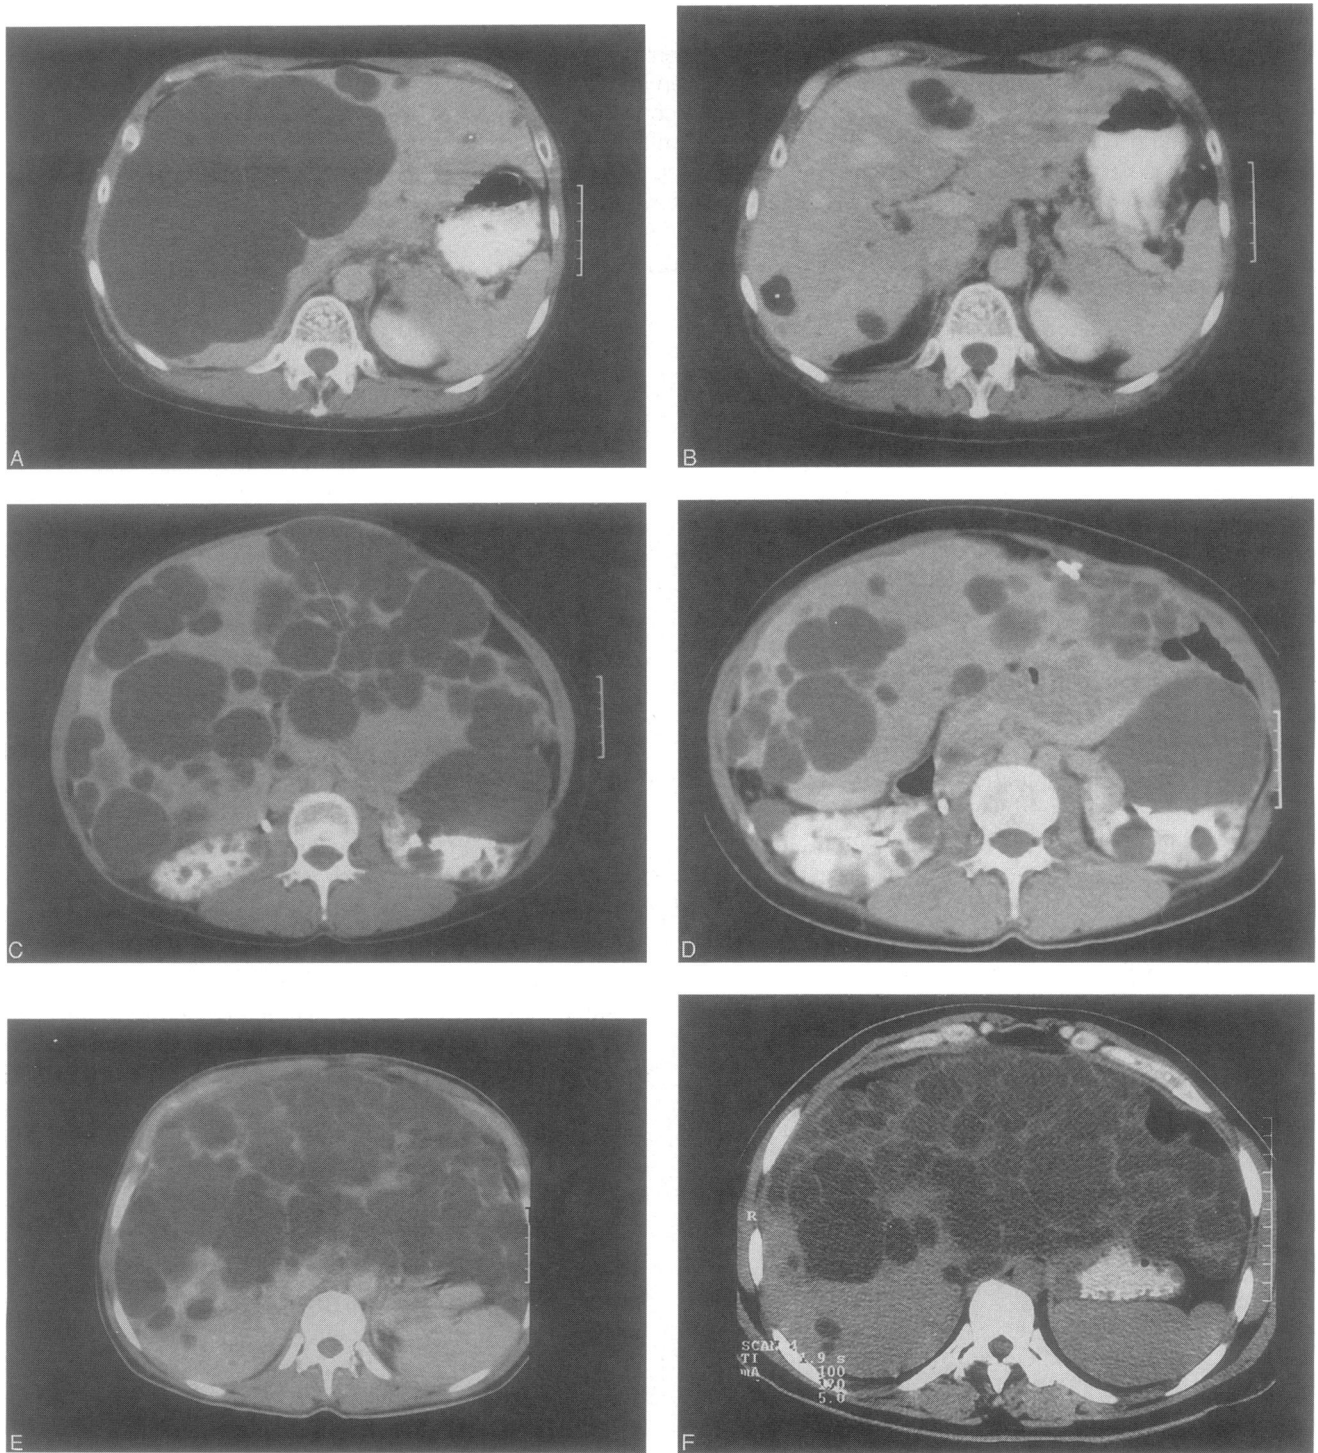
Suggested classification of patients with adult polycystic liver disease (APLD) according to number, size, and location of cysts within the liver, and the amount of residual normal liver parenchyma on preoperative computed tomography (CT). (A) Type I APLD. Limited number (<10) of large cysts (>10 cm). Preoperative CT and postoperative CT (B). (B) Type II APLD. Diffuse involvement of liver parenchyma by multiple medium-sized cysts with remaining large areas of noncystic liver parenchyma. Preoperative CT (C), postoperative CT (D). (C) Type III APLD. The most severe form of APLD with massive, diffuse involvement of liver parenchyma by small- and medium-sized liver cysts, with only a few area of remaining normal liver parenchyma between cysts. Preoperative CT (E) and postoperative CT (F).
